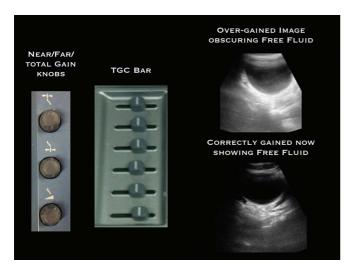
Reducing far gain to minimize posterior acoustic enhancement. Traditionally, mobile cart-based machines feature 3 knobs of gain adjustment. The top knob adjusts the gain for the top half of the screen; the middle knob adjusts gain for the bottom half of the screen; and the bottom knob adjusts gain for the entire screen. There is also an "auto gain" button (not shown) that adjusts gain to default levels. Time-gain compensation bars serve similar functions on traditionally larger and more sophisticated suite-based machines. The distinction between time-gain compensation bars and gain knobs continues to blur with touchscreen displays and handheld ultrasound systems.
